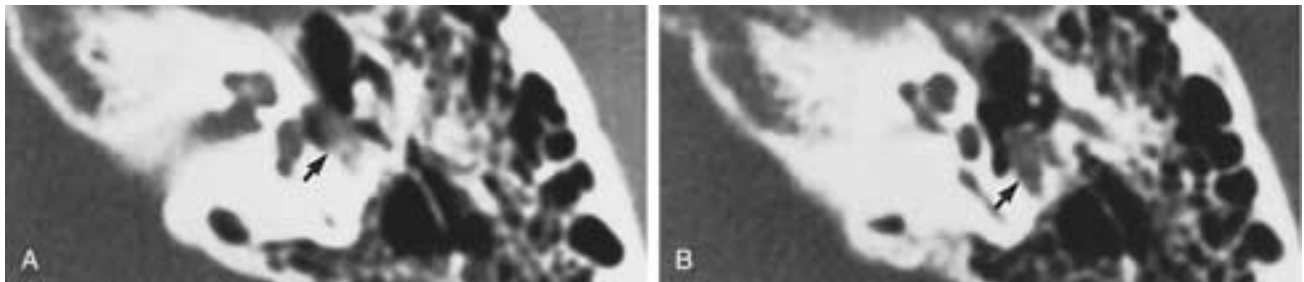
Tympanic segment facial schwannoma. A and B, Axial CT. Tumor (*arrow*) arising from the posterior genu region caused conductive hearing loss. Other tumors that may be similar in appearance include intratemporal cholesteatoma. (See also [Fig. 25-89](#).) (Courtesy of Dr. Lyle Wendling.)
